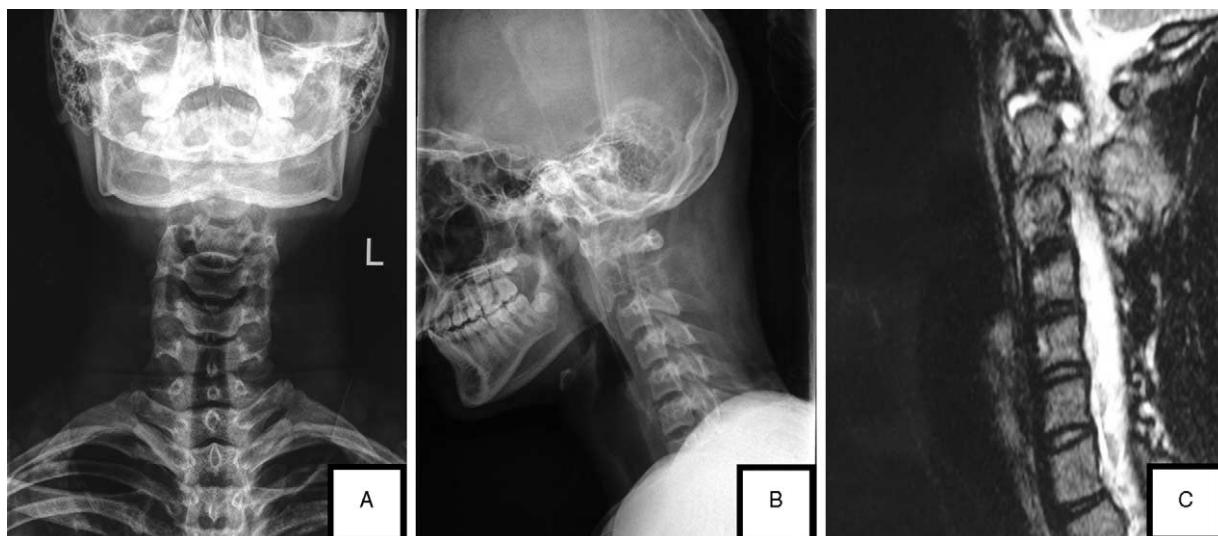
A and B, Preoperative X-rays demonstrated a lytic lesion surrounded by peripheral osteosclerosis involving the entire axial vertebra. C, MRI demonstrated paravertebral soft tissue involvement.
